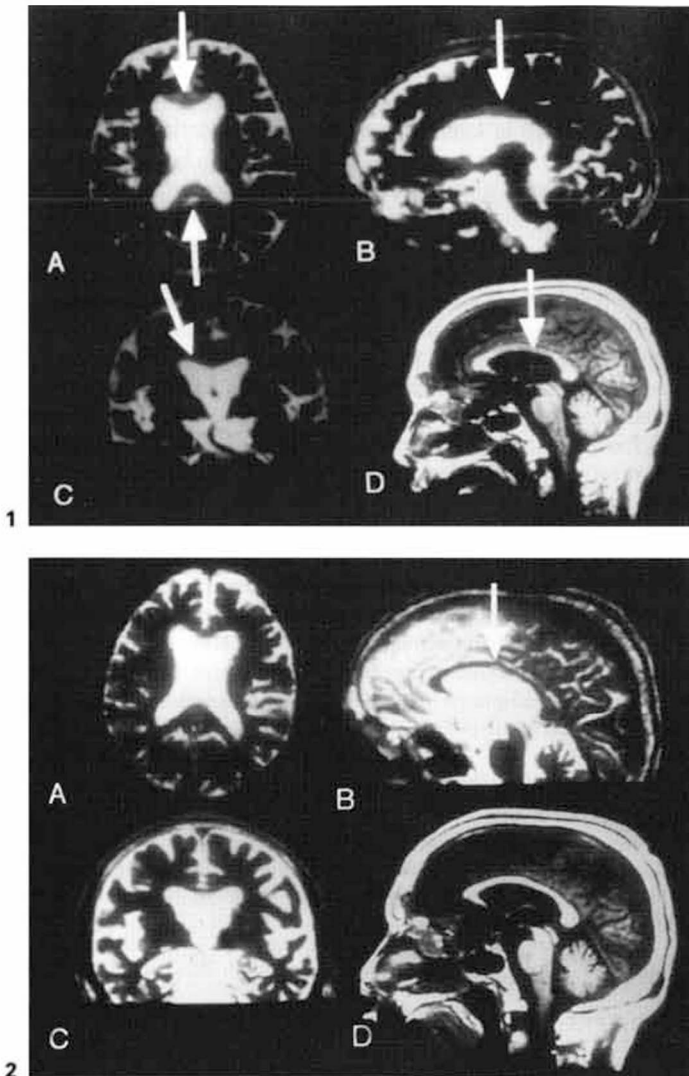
Cranial MRI on March 3, 1994. A T2-weighted MRI in the axial (A), the sagittal (B), and the coronal image (C) revealing hyperintensity of the corpus callosum. A T1-weighted MRI in the sagittal plane demonstrating hypointensity of the middle portion of the corpus callosum, the genu and splenium (D).
